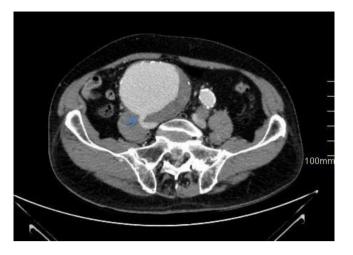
Computed tomography angiography (Coronal view). Isolated right iliac artery aneurysm with contained rupture. Blue arrow is pointing to fistula to the venous system
